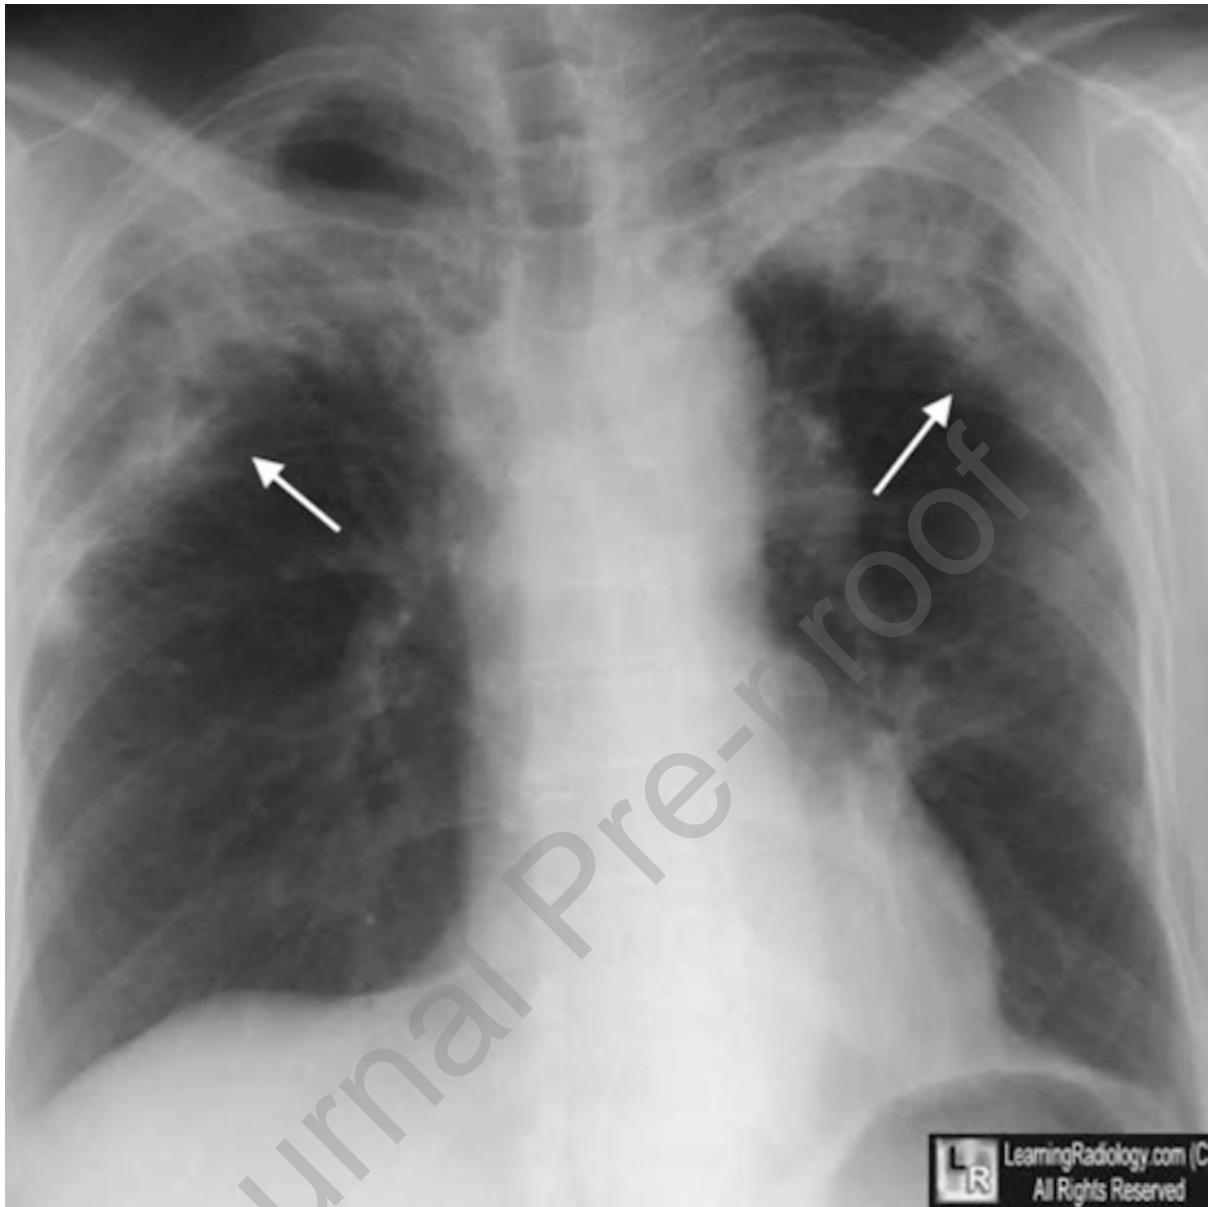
Chest radiograph in Löffler's (Loeffler's) Syndrome. There are bilateral peripheral infiltrates in the upper lung fields. This has been called the reverse pulmonary oedema sign. Published with permission from *LearningRadiology.com*
